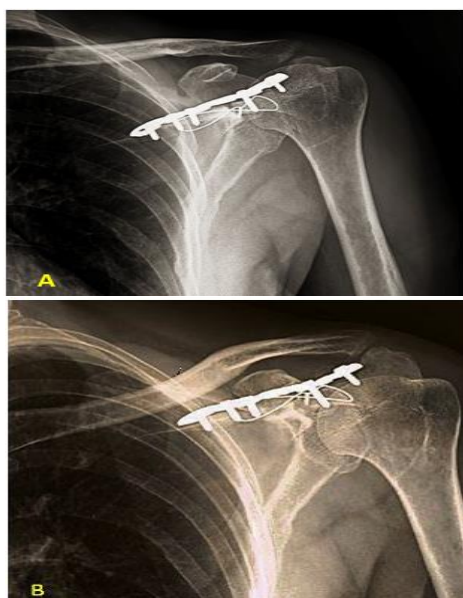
Early post operative antero-posterior and lateral X-ray demonstrating anatomic reuction of scapular spine
